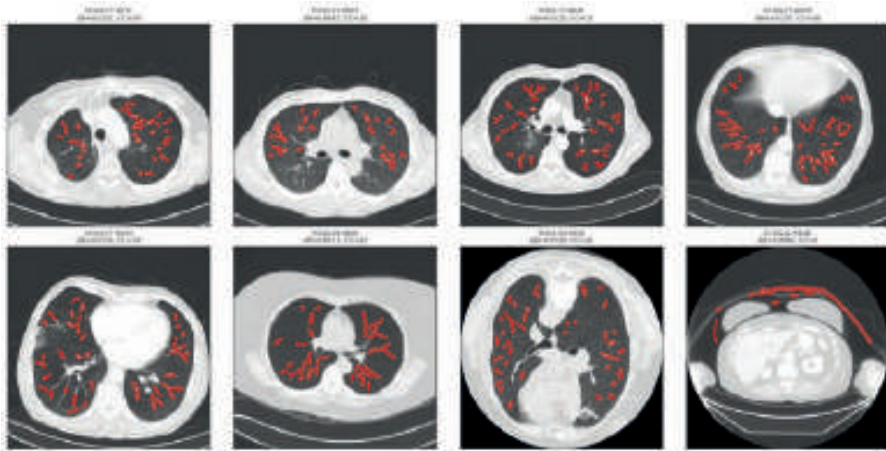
Lesion candidate localization within lung CT images. Red markers indicate regions used for localized compression fidelity analysis.
